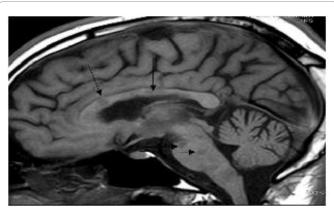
MRI T1-weighted sequence: Black hole in the white matter corpus callosum and pons.
